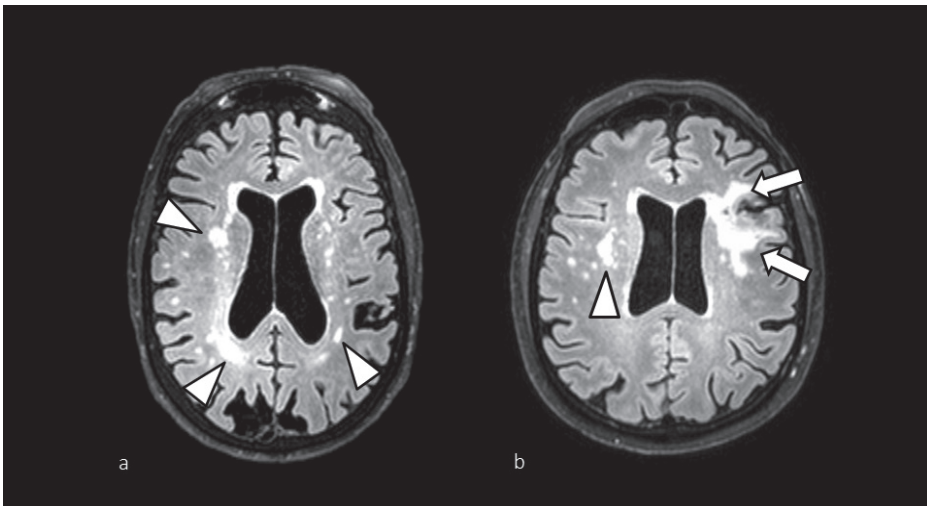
Two example figures of neurovascular brain changes. An example patient (a) of larger (arrowheads) and smaller white matter hyperintensities on a T2 weighted axial Fluid Attenuated Inversion Recovery (FLAIR) image. Some atrophy is also present with brain sulci clearly visible and central atrophy with ventricle enlargement. Another example patient (b) with a combination of white matter matter hyperintensities (arrowhead) and a larger cortical-subcortical infarct (arrows) on a T2 weighted FLAIR image.
